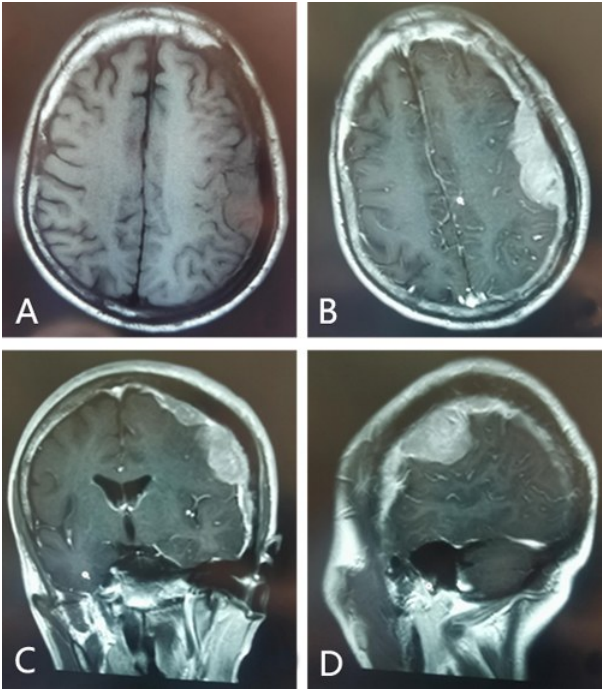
左侧额颞顶部硬膜前列腺来源的转移性病变术前 MRI 表现
